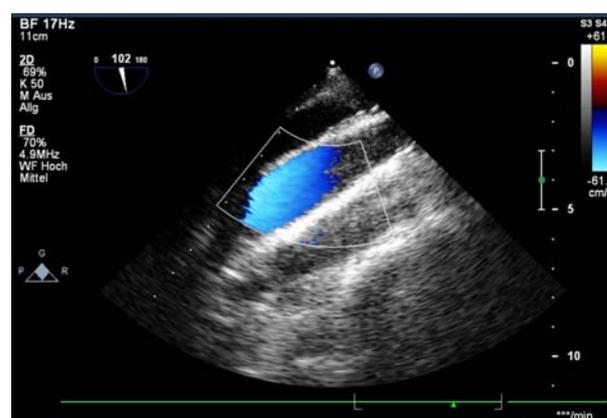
Transesophageal echocardiography before resection.
